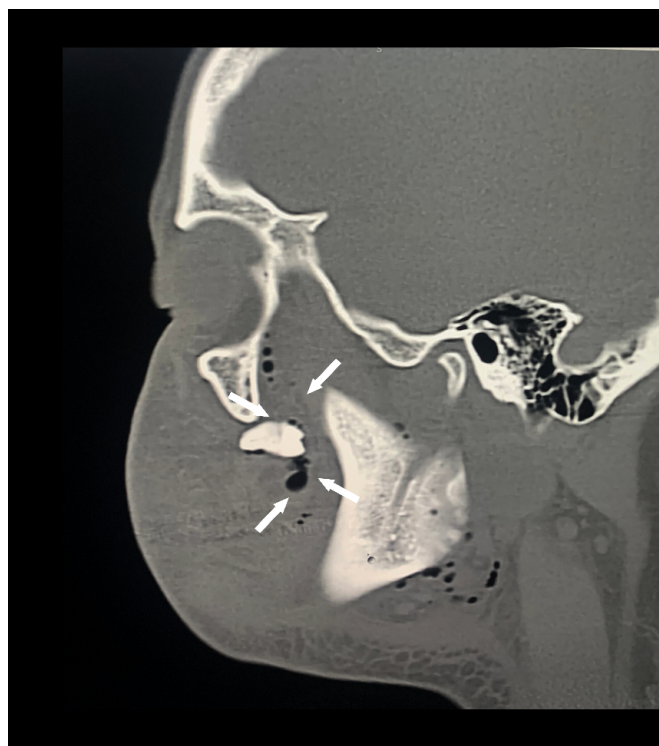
Contrast-enhanced computed tomography scan (CT), sagittal section. Three-plane evaluation of left maxillary third molar displaced into the infratemporal space (white arrows).
